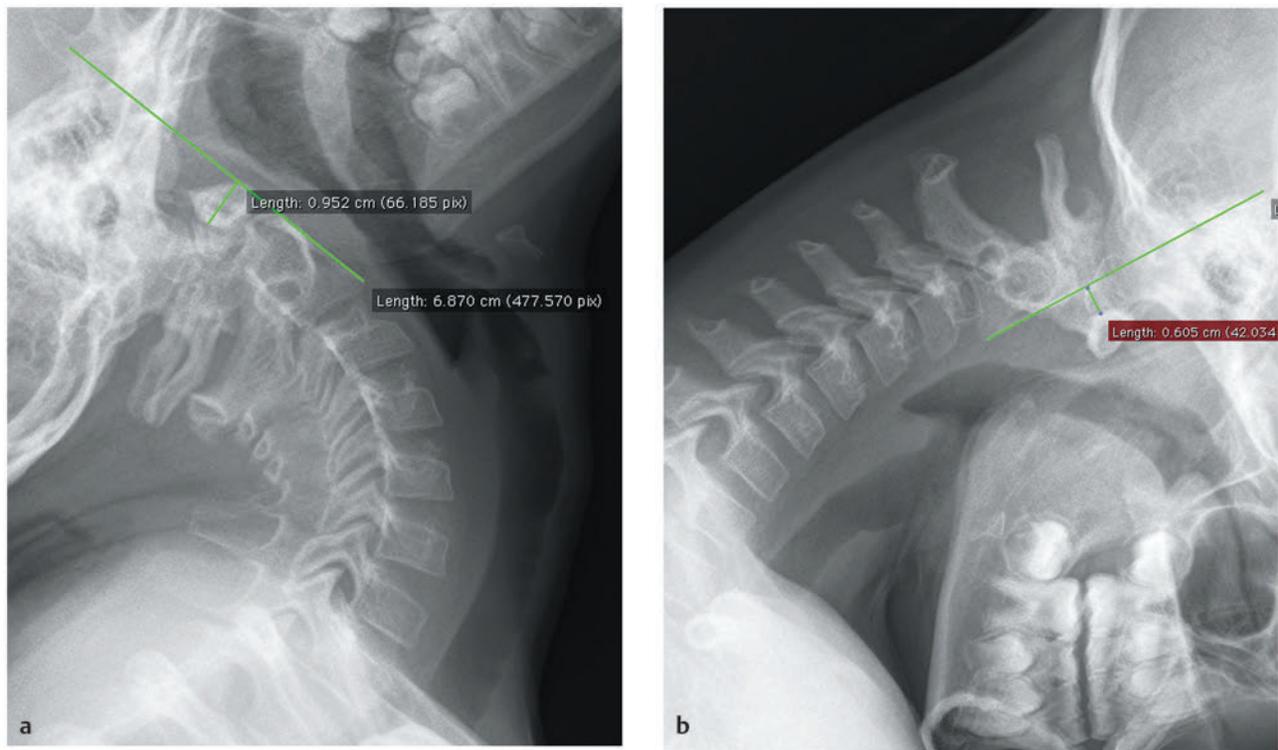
Os odontoideum. Preoperative (a) extension and (b) flexion radiographs demonstrating gross instability with 15 mm of subluxation at C1–2 in a 9-year-old boy with os odontoideum who presented with vertebrobasilar insufficiency.
